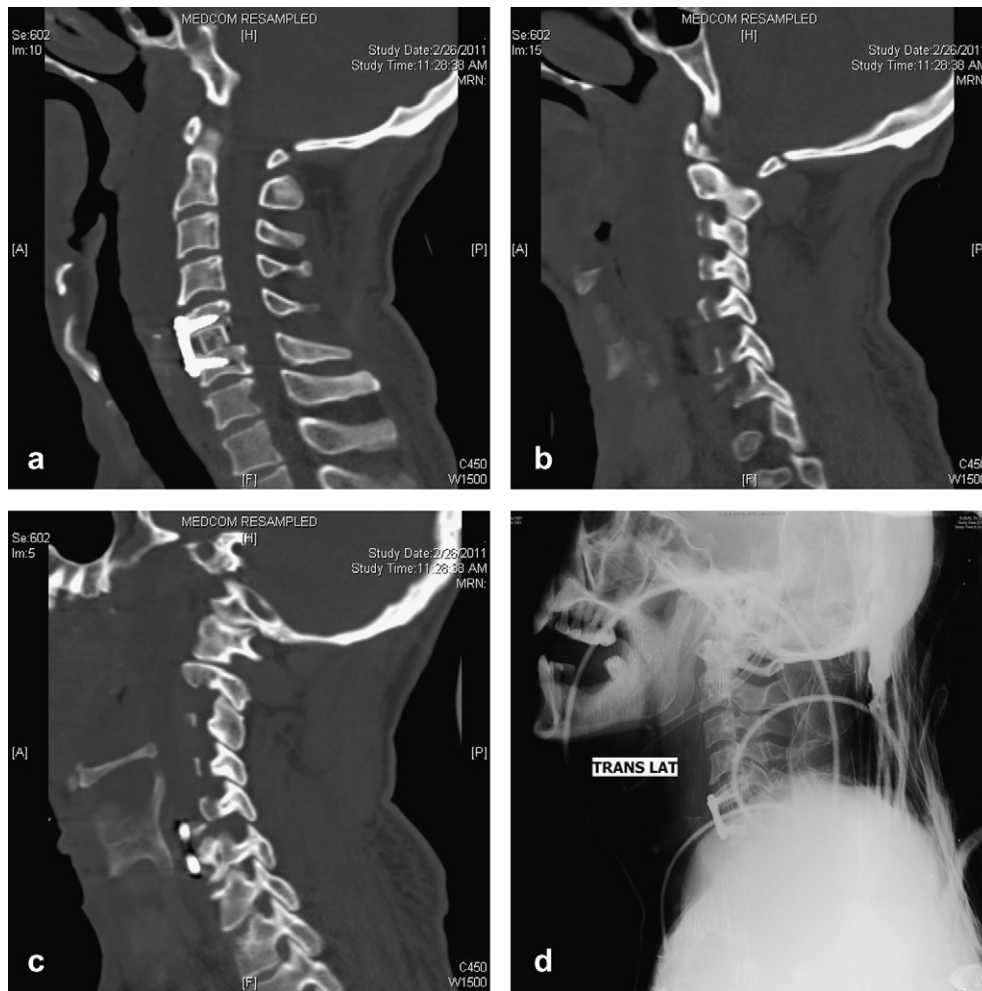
Postoperative images. a. Sagittal NCCT showing C5/C6 Discectomy with PEEK cage and plate with restoration of alignment. b & c. Reduction of dislocated facets bilaterally. d. X-ray cervical spine lateral view.
